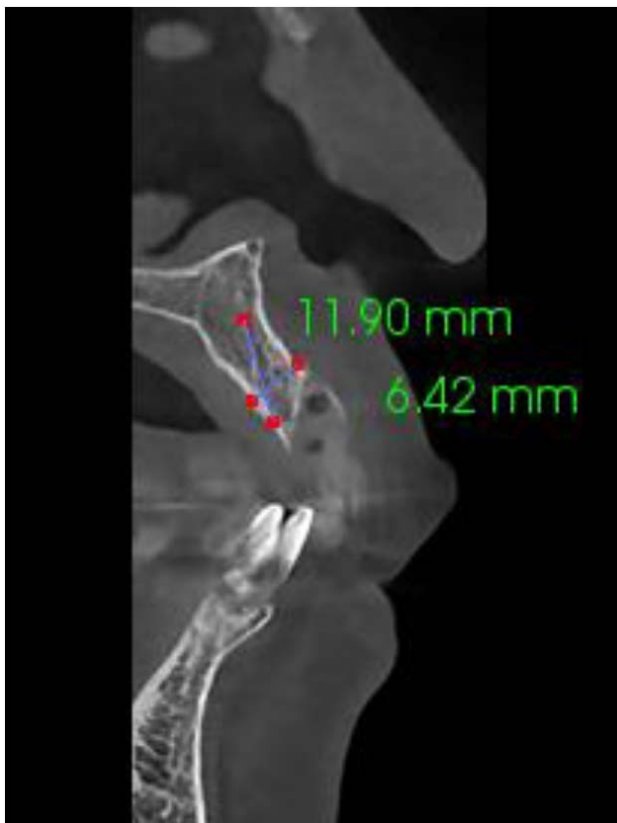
CBCT scan image for implant placement planning.
